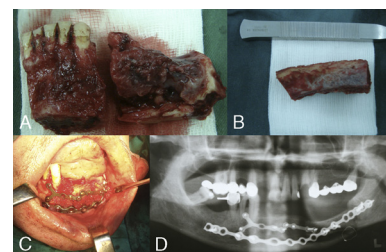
A, Extracted segments in 2 pieces. B, Iliac crest bone graft. C, Intraoperative view after reconstruction plate and bone graft placement. D, Orthopantomographic view after the operation.
